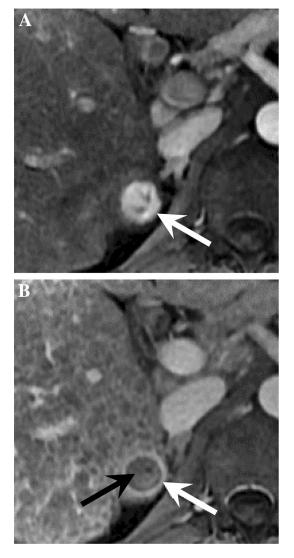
Major features of HCC. Contrast-enhanced MRI shows a 25 mm observation in a cirrhotic liver exhibiting nonrim arterial phase hyper-enhancement (white arrow) in the arterial phase (A) and nonperipheral "washout", and enhancing "capsule" (white arrow) in the delayed phase (B), categorized LR-5.
